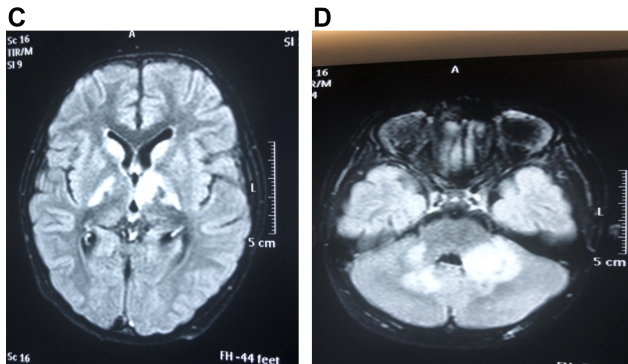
An MRI of the brain showing bilateral basal ganglia hyperintensity in a case of anti-MOG antibody syndrome (C). An MRI of the brain showing a cerebellar demyelinating lesion in a case of anti-MOG antibody syndrome (D).
